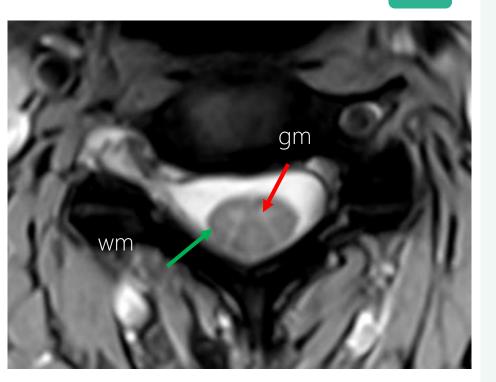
Anatomy of the spinal cord as seen on an axial T2weighted MR image.
